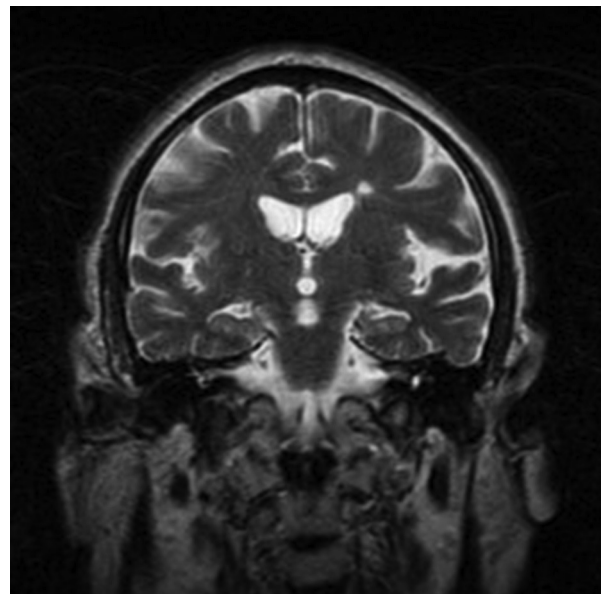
Head magnetic resonance imaging reporting multiple bilateral ischemic lesions and small old infarcts, predominantly subcortical located in the white matter of both hemispheres.
